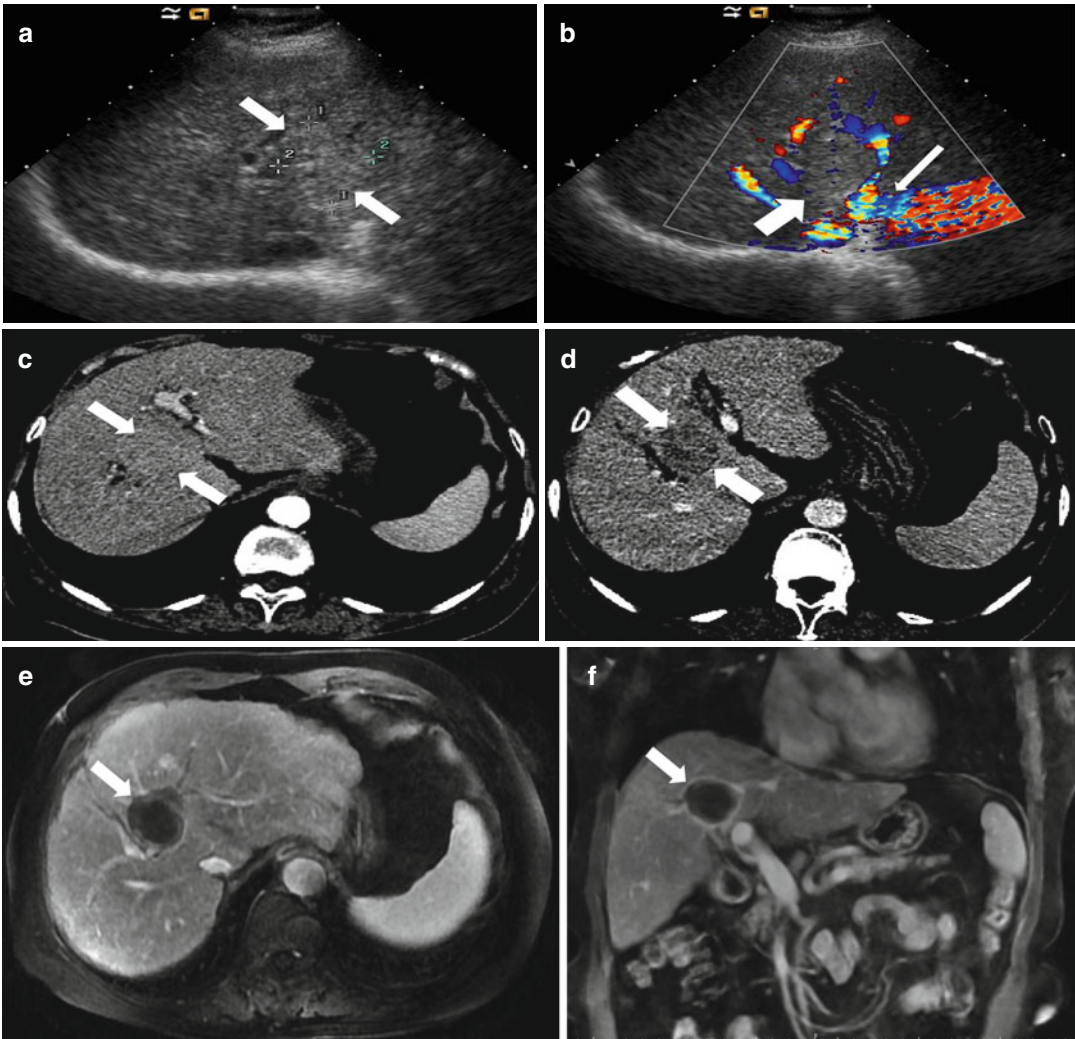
Microwave ablation (MWA) in a 75-year-old woman with liver tumor (3.3×3.1 cm) adjacent to the hepatic hilum. (a) Grayscale ultrasonography before MWA showed an isoechoic tumor adjacent to the hepatic hilum (arrow). (b) Color Doppler showed tumor (arrow) adjacent to portal vein (narrow arrow). (c) Contrast-enhanced computed tomography (CT) before MWA showed mild enhancement of the tumor in arterial phase
